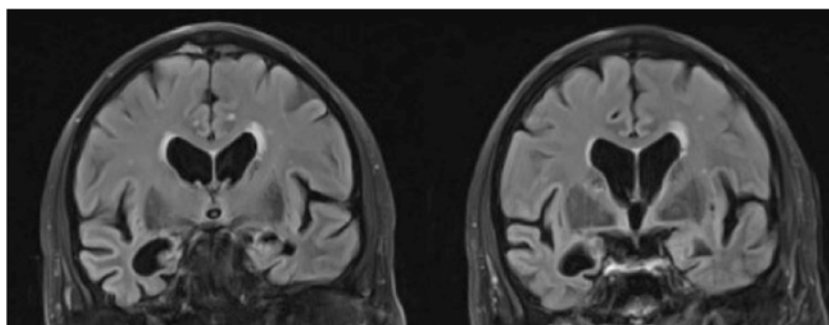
Coronal FLAIR images in a patient with a right temporal variant of bvFTD . There is marked asymmetrical volume loss of the right temporal lobe affecting all the temporal gyri and resulting in marked
